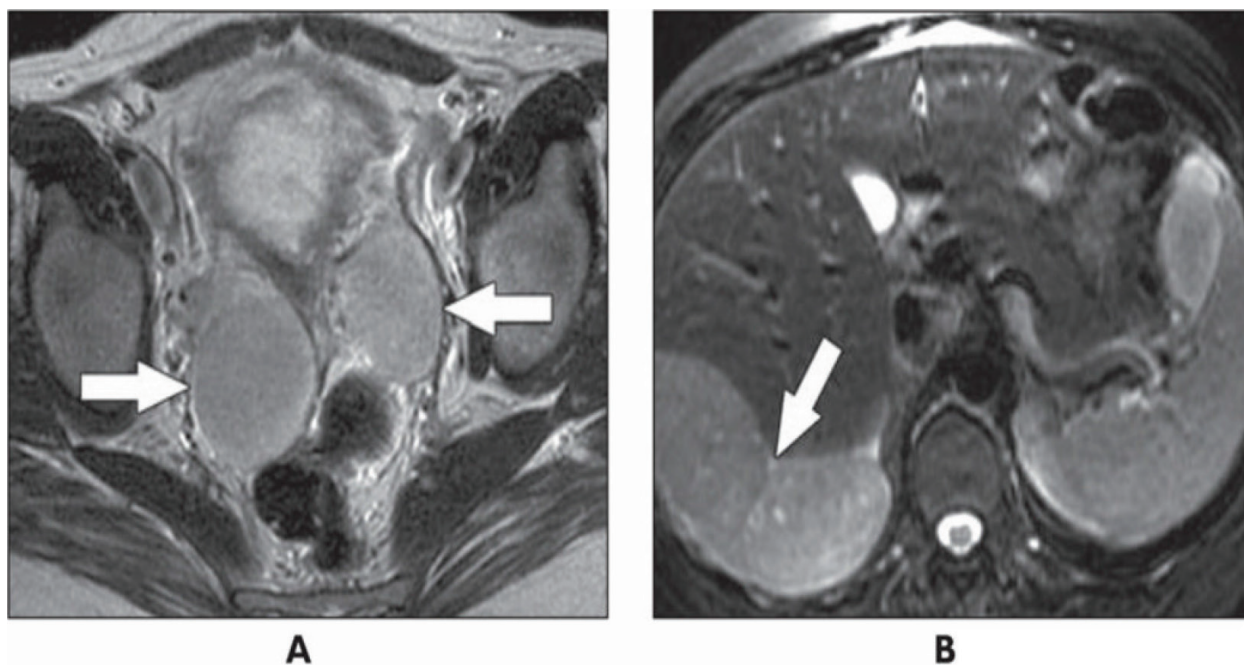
A 34-year-old pregnant woman. (A) Axial RARE T2-weighted MR image obtained at 23 weeks' gestation shows bilateral solid adnexal masses (arrows). (B) Axial RARE T2-weighted MR image through upper abdomen shows large tumor deposit (arrow) abutting liver. Appearances are considered indicative of malignancy. Cesarean hysterectomy and bilateral salpingo oophorectomy were performed at 28 weeks' gestation because of progression of subphrenic tumor with diaphragmatic irritation. Pathology results showed benign metastasizing leiomyoma. Masses spontaneously regressed after surgery and patient remains free of disease 3 years after surgery.
